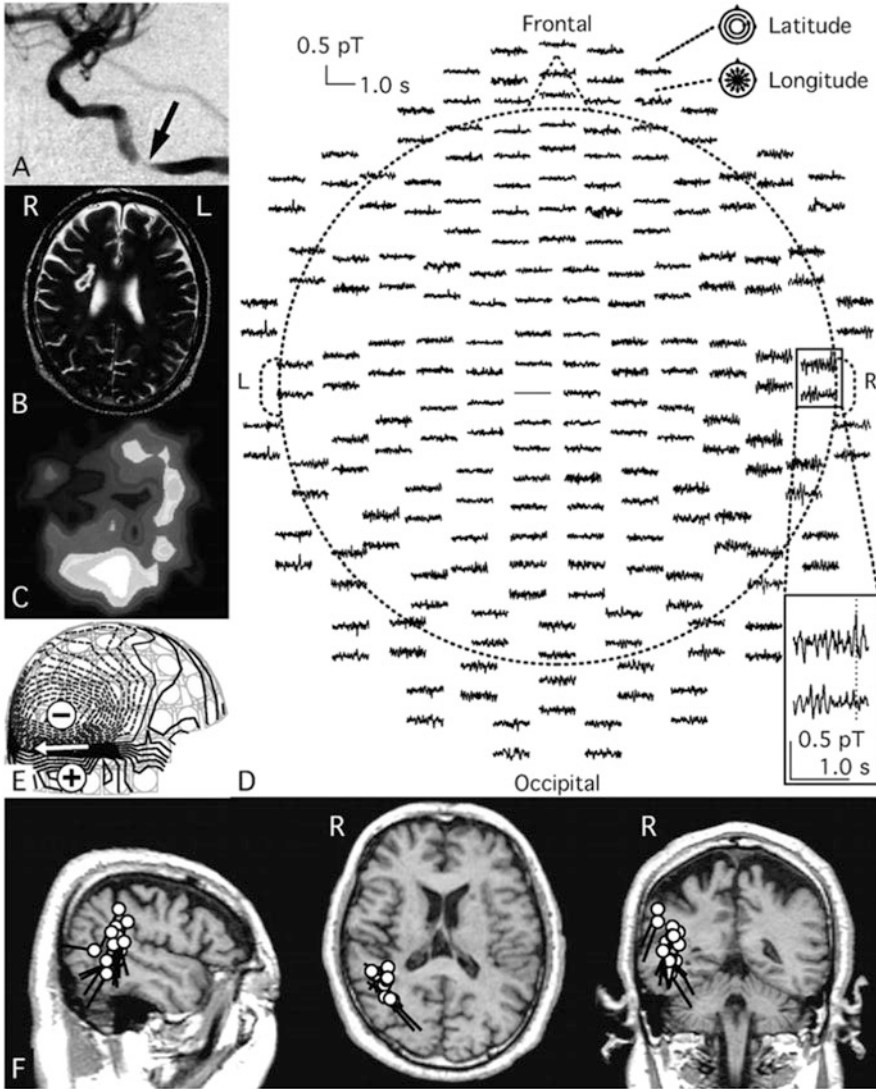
A 54-year-old male with temporoparietal theta activity (TPTA) detected by MEG. (a) Digital subtraction angiogram showing stenosis (*arrow*) of the right internal carotid artery. (b) T2-weighted MR image showing a right striatocapsular infarct lesion. (c) SPECT scan showing flow reduction in the territory of the right middle cerebral artery. (d) MEG waveforms, detected in the awake condition with the eyes closed using the latitudinal and longitudinal tangential derivatives of 204 planar-type gradiometers, showing TPTA in the right hemisphere. (e) Isofield map at a typical peak of TPTA (*broken line* in the inset square of D), showing a single dipole pattern. The *arrow* shows the approximate location and orientation of the equivalent current dipole (ECD) of TPTA over the right temporal area. (f) ECDs at ten similar peaks of TPTA to (d) and (e) projected onto three orthogonal MR images. *Circles and bars* indicate the ECD location and orientation, respectively (Ohtomo et al. [15])
